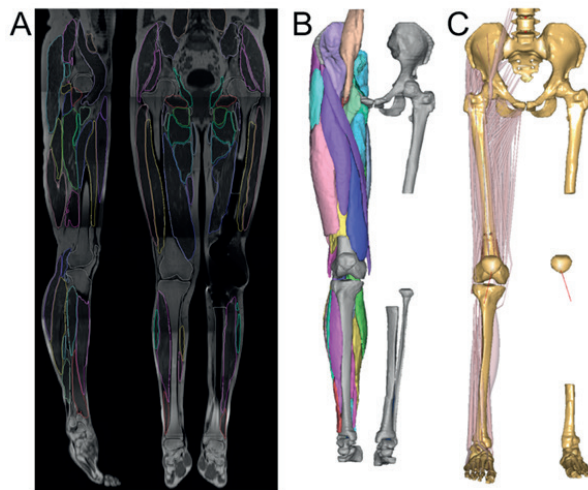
A: Example of the results of semi-automatic segmentation of muscles from MRI scans. B: Three-dimensional visualization of the segmented bones and muscles. C: Image-based post-operative subject-specific musculoskeletal model that has been based on the segmented bones and muscles from the MRI scan and the surgical log. Only the muscles of the right limb are shown.
